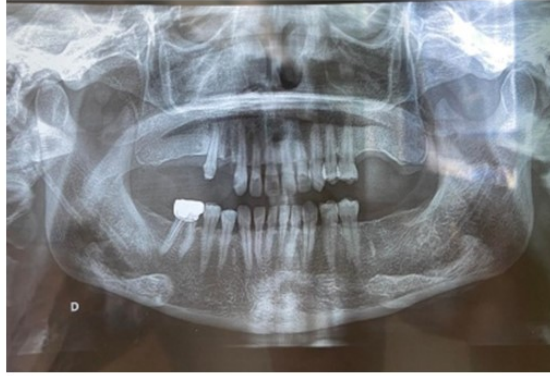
The Panoramic Radiograph
